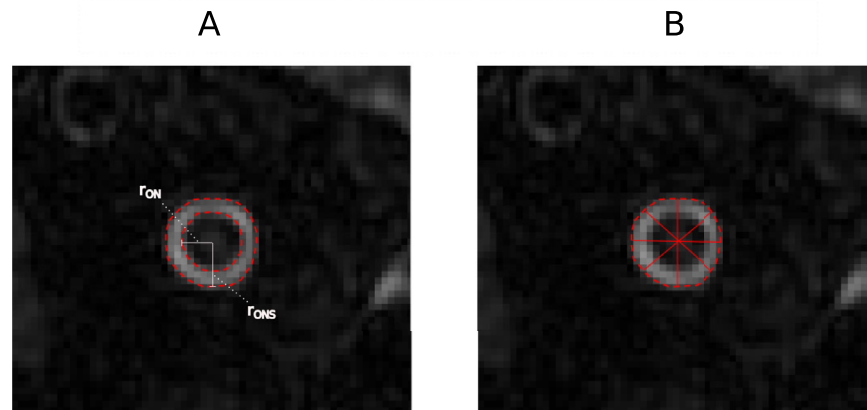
MRI image of the ONSAS segmentation. (A) Volume. (B) Diameter (average of four directions). The ONSAS radius r_{ONS} and optic nerve radius r_{ON} are also highlighted.
